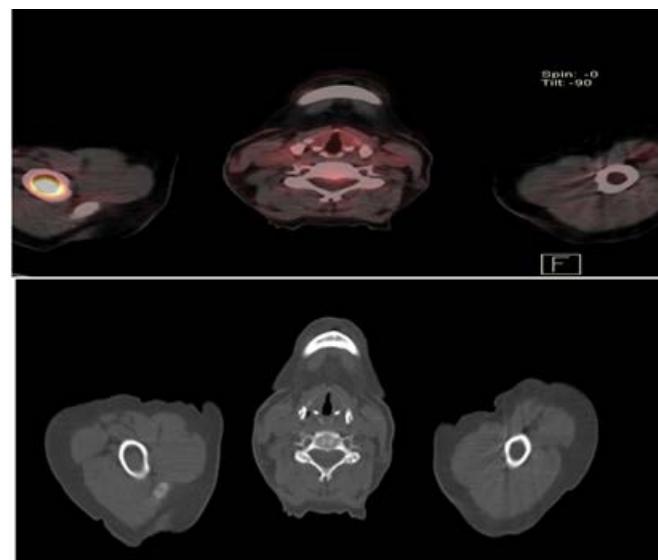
9: CT and PET images that show right humeral bone lesion with high radiotracer uptake only visible on PET.
